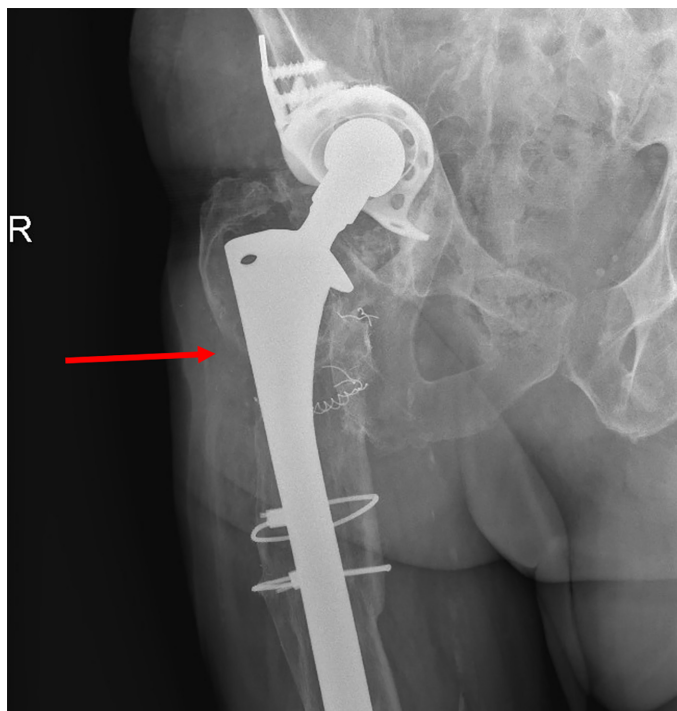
Pre-surgical x-ray of the right pelvis prior to bacteriophage administration. Note the extent of hardware in place and the loss of bone in the lateral subtrochanteric region (arrow)
